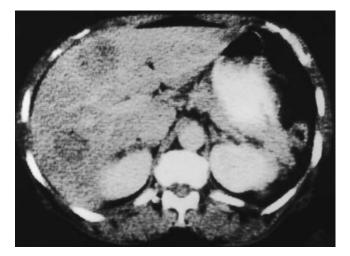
Computed tomographic scan showing liver metastases from a primary small bowel neuroendocrine tumor.
